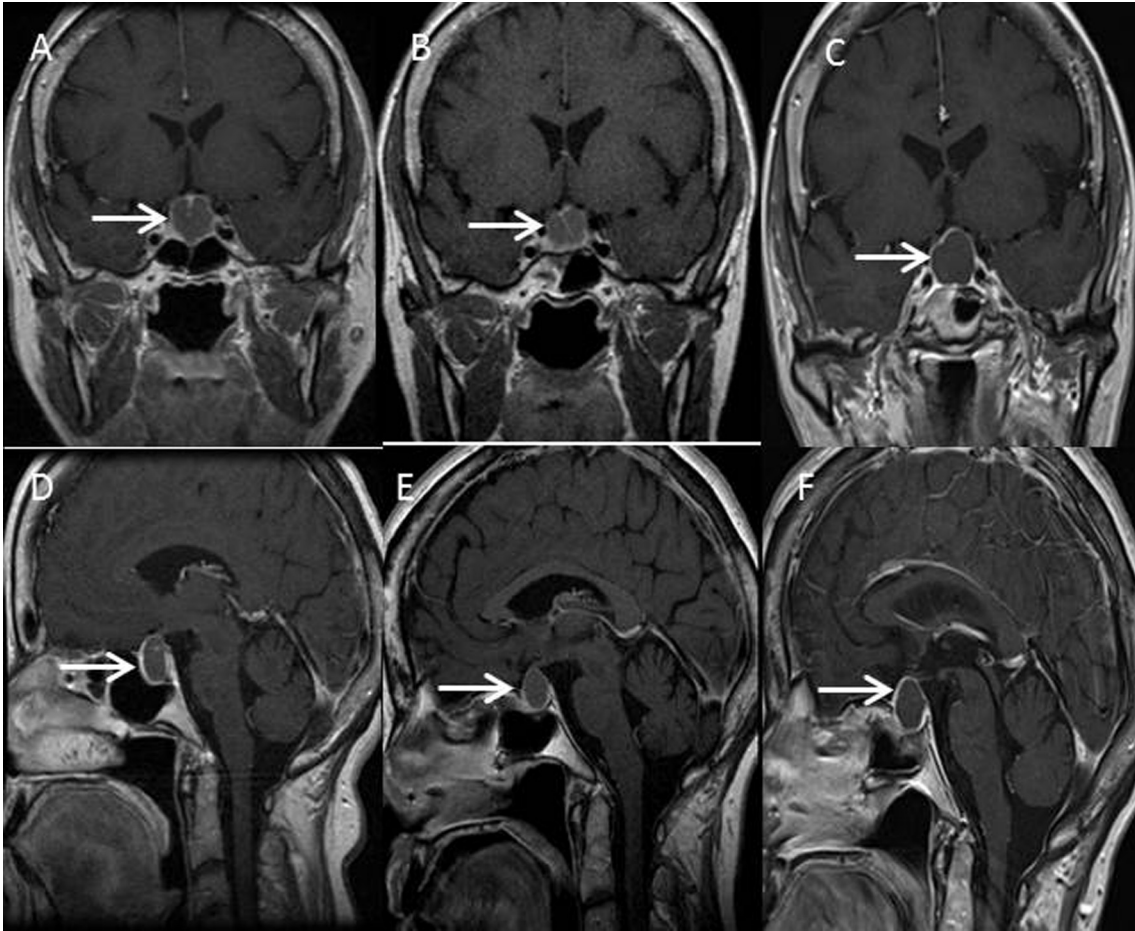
T1-weighted MRI with contrast (A) coronal and (D) sagittal, at initial presentation showing a ring enhancing cystic Rathke's cleft cyst (RCC) (white arrow). T1-weighted MRI with contrast (B) coronal and (E) sagittal, 3 years after first resection showing the first recurrence of the RCC. T1-weighted MRI with contrast (C) coronal and (F) sagittal, 7 years after first resection showing increased size of the RCC with elevation of the optic chiasm.
